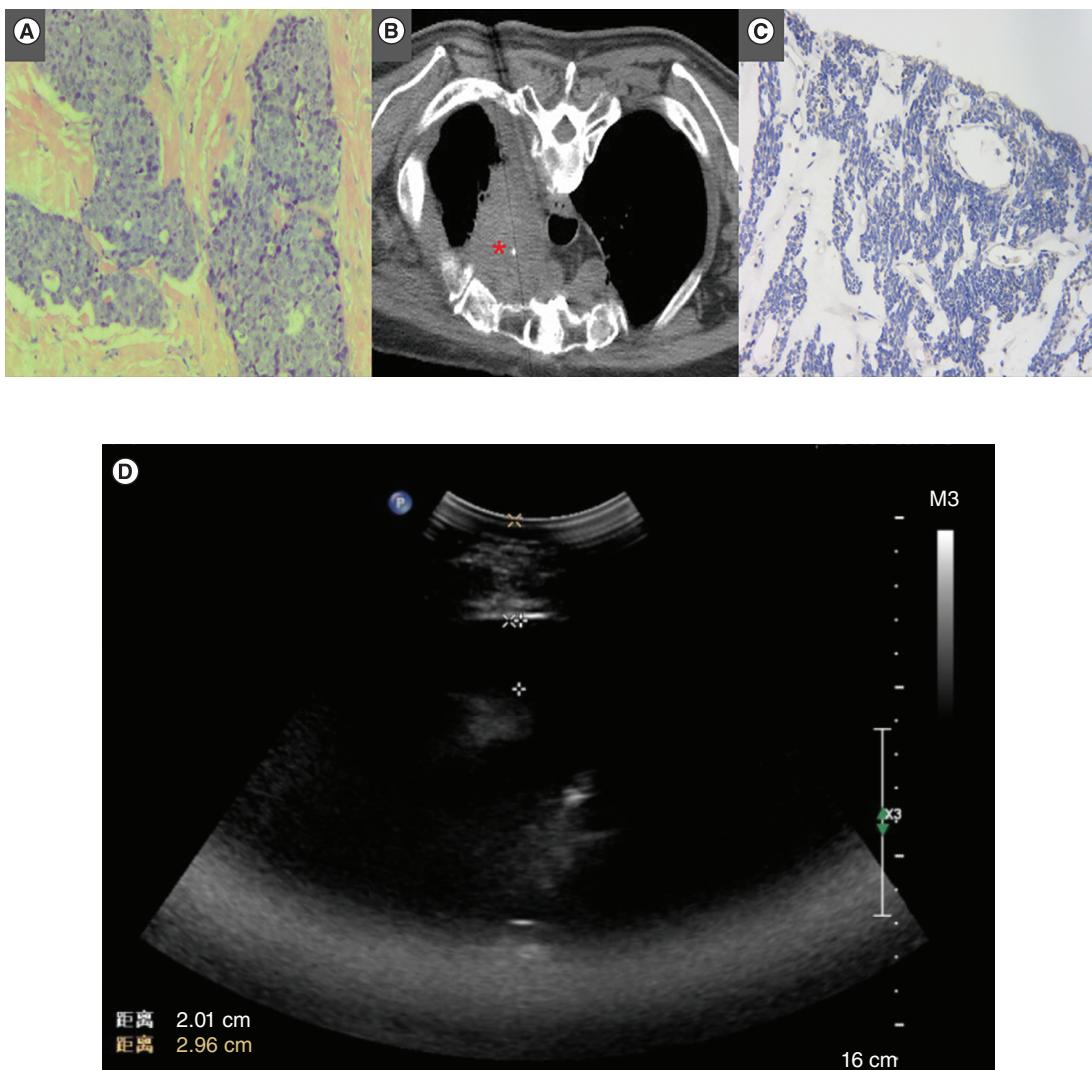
Characteristic of patient 3. (A) Pathological diagnosis of case 3 was WHO thymic carcinoma. (B) Progressed mass in the anterior mediastinum. (C) Negative PD-L1 expression. (D) Ultrasonographic scanning showed massive presence of pericardiac fluid.
